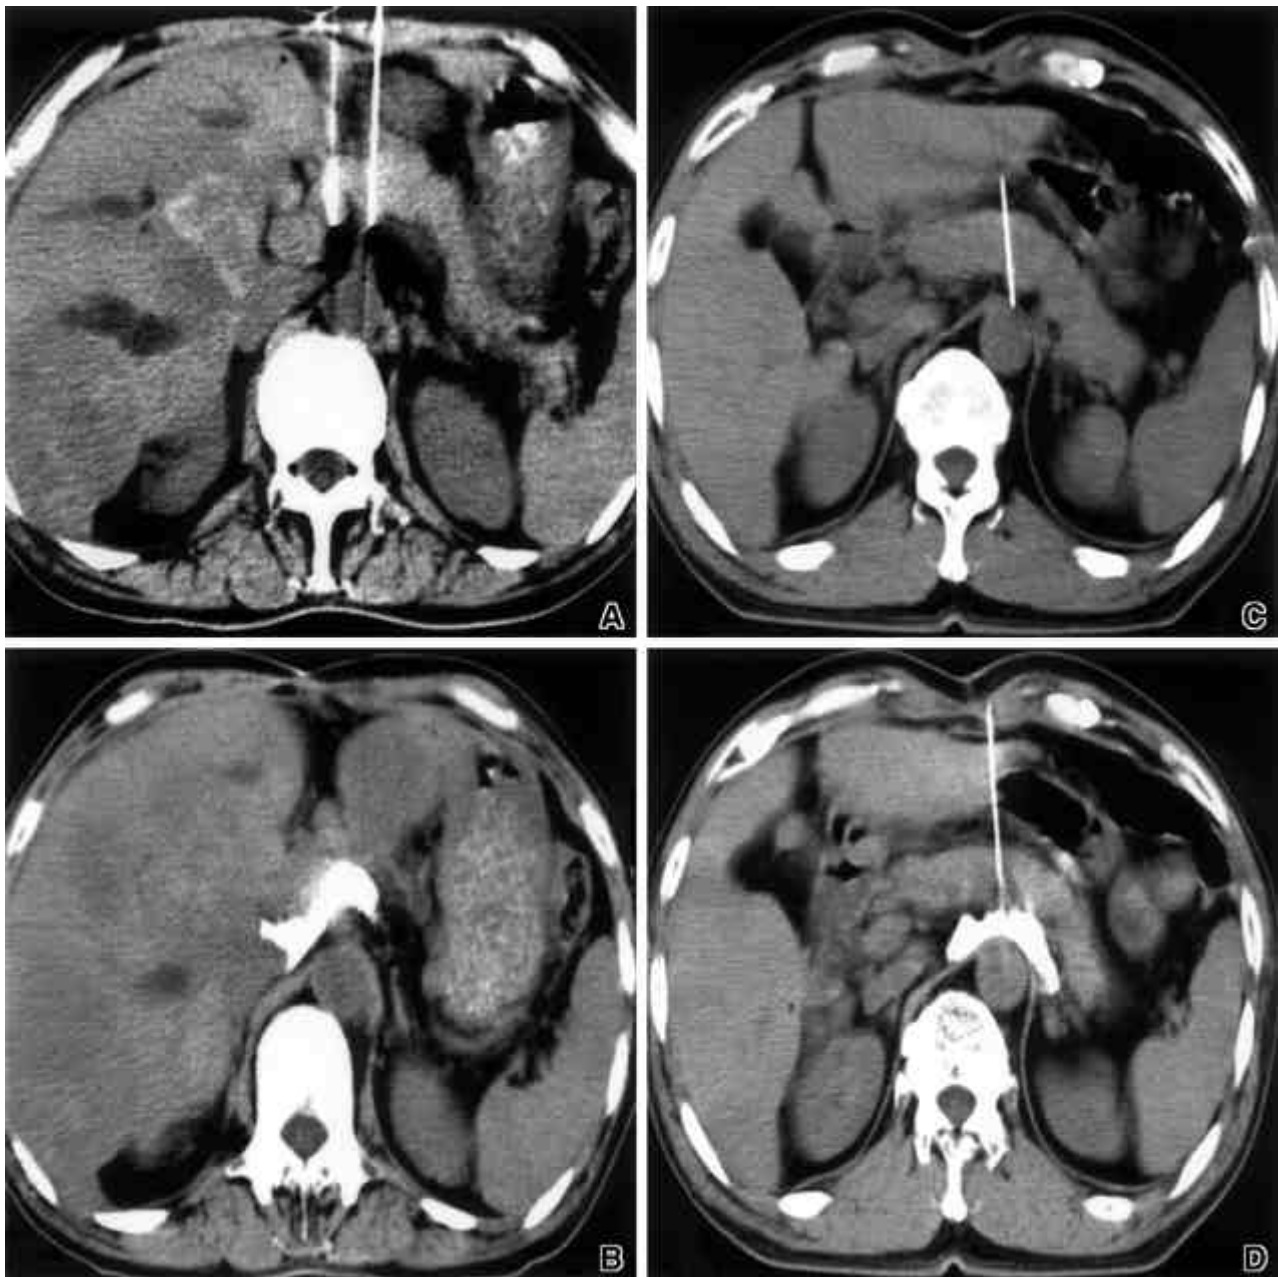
Anterior approaches. Two needle technique: CT scan shows two 15-cm, 21-gauge Chiba needles, one on each side of the superior mesenteric artery (A), and contrast material diffusing around the superior mesenteric artery and aorta from both needle tips (B). Single needle technique: CT scan shows tip of needle is placed anterior to the aorta between the celiac axis and superior mesenteric artery (C), and spread of the contrast material around the aorta (D).
